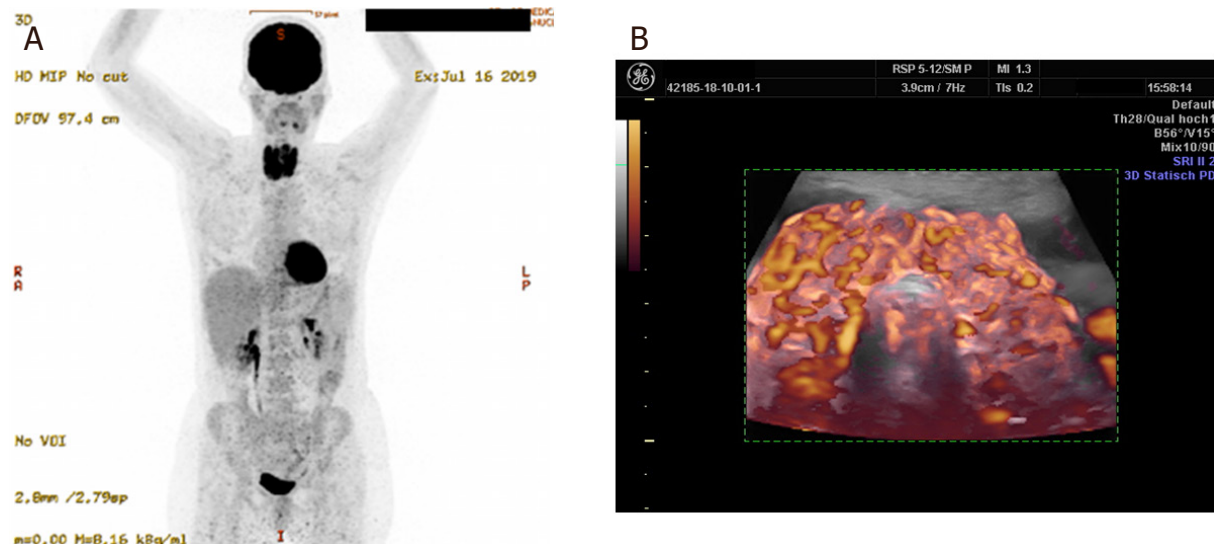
Woman with chronic relapsing thyroiditis, showing increased uptake of ^{18}F -FDG in the thyroid and the heart in a PET examination (A). This tracer uptake pattern indicates glycolytic metabolism of the organs. On 3D power Doppler sonography (B), one can recognize the marked perfusion changes that correspond to CoQ₁₀ deficiency, showing enlarged vessels
